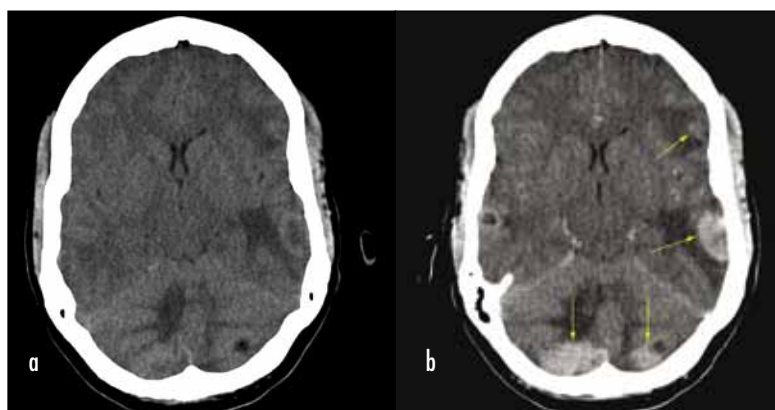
a. A pre-contrast computed tomography scan with multiple mixed attenuation lesions in both cerebral hemispheres with associated mass effect. b. The same patient following contrast infusion, with multiple enhancing metastases seen throughout the brain parenchyma (yellow arrows). Note many of these lesions were invisible on the pre-contrast scan.
